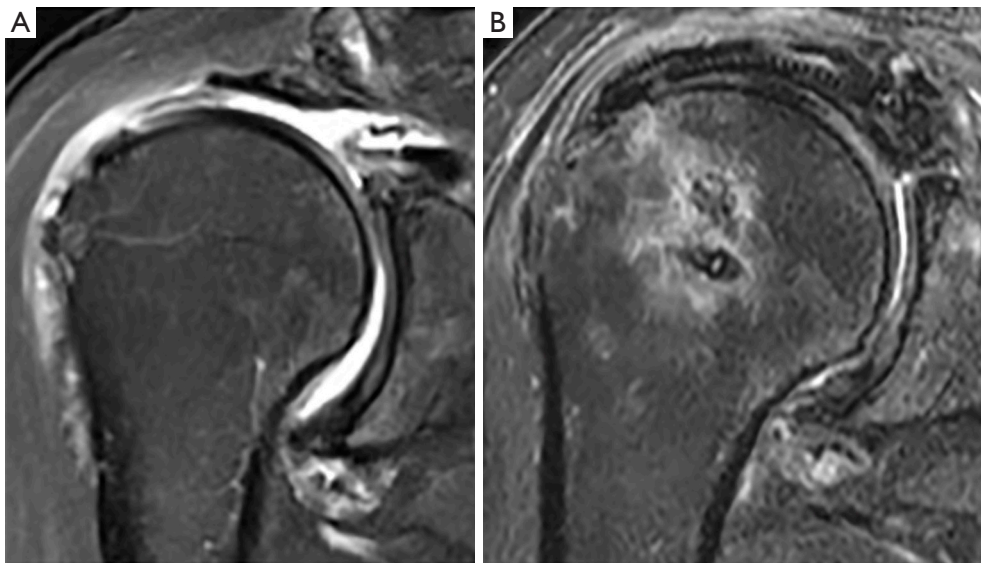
Preoperative T2-weighted MRI in coronal plane of a massive rotator cuff tear (A) and 12 months postoperatively (B) showing an intact graft.
